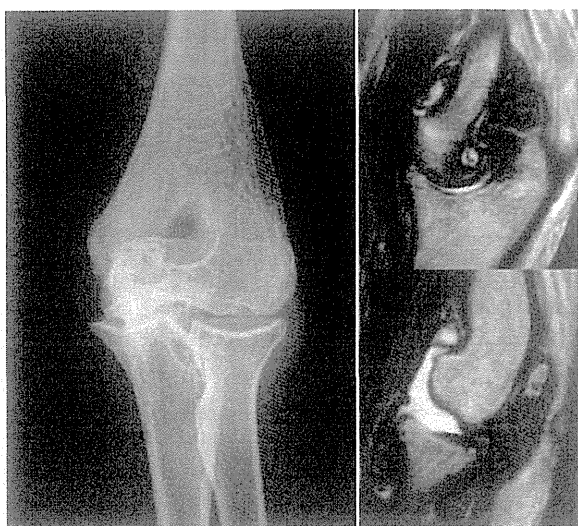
Preoperative AP radiogram and MRI T2-weighted sagittal images of the left elbow show erosive change on the articular surface, hypertrophy of synovium and correction of joint effusion.
